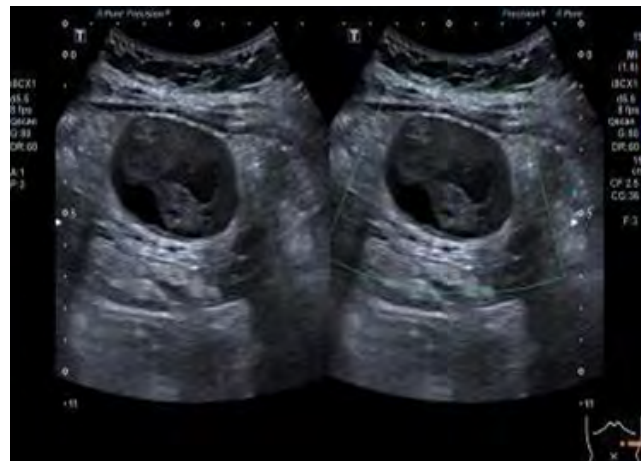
Ultrasound - The size of the mixed cyst solid lesion in the omentum of the left upper abdomen was about 5.20cm × 4.00cm × 4.30cm.
